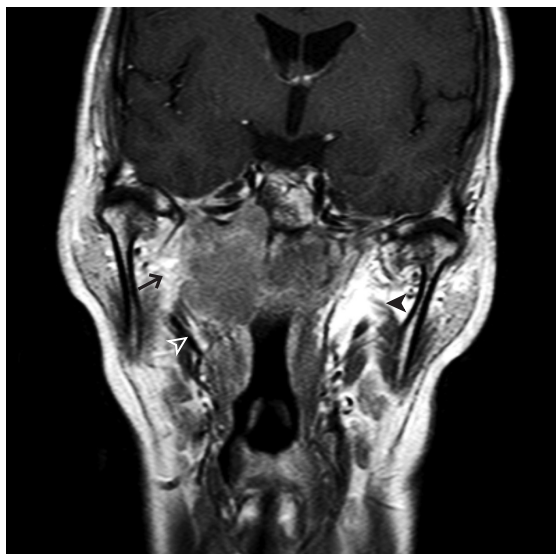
Coronal Post-Gd T1 W MRI shows a large nasopharyngeal carcinoma extending laterally to the right parapharyngeal fat space (→). Note the contralateral normal parapharyngeal fat space on the left side (▲). There is inferior extension to the right side of oropharynx (△).
